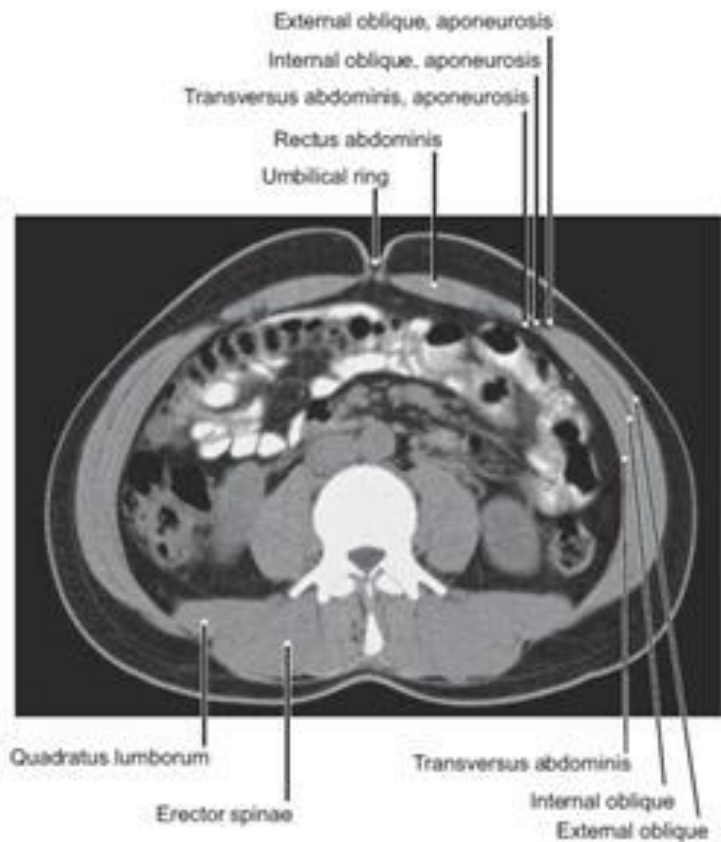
Computed Tomography (CT) of the Muscles of the Abdomen at the Level of the Umbilicus
